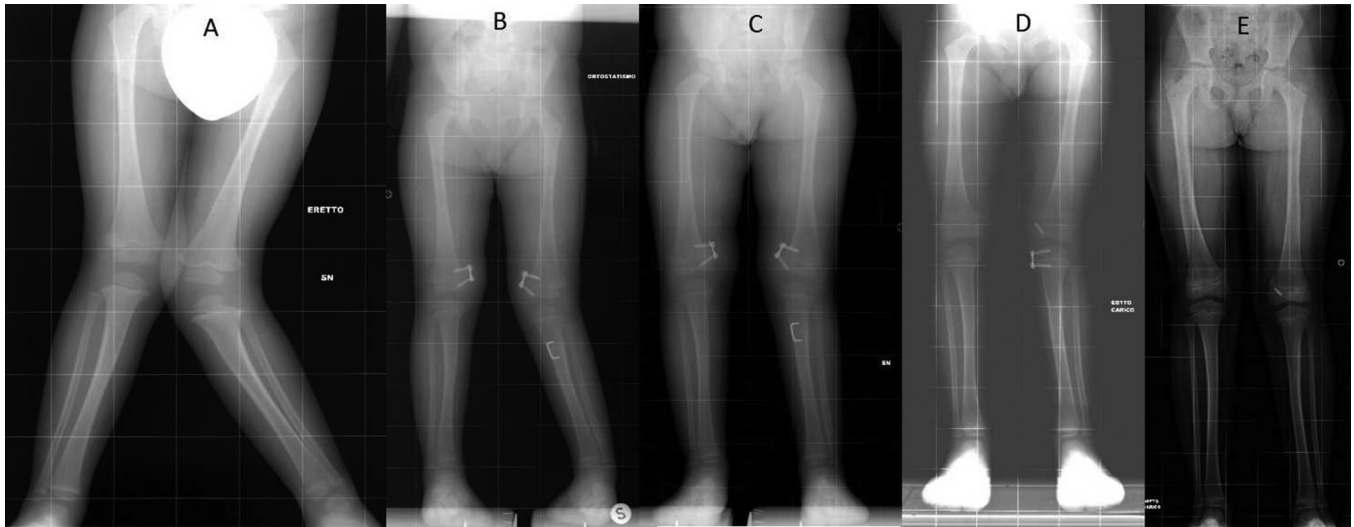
Patient radiograph evaluation: (a) pre-operatively at age two years 11 months; (b-d) periodic follow-up after surgery; (e) at final follow-up at eight years of age.
